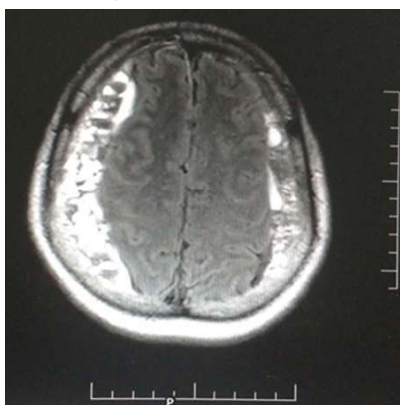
MRI scan showing massive bilateral subdural hematoma.
